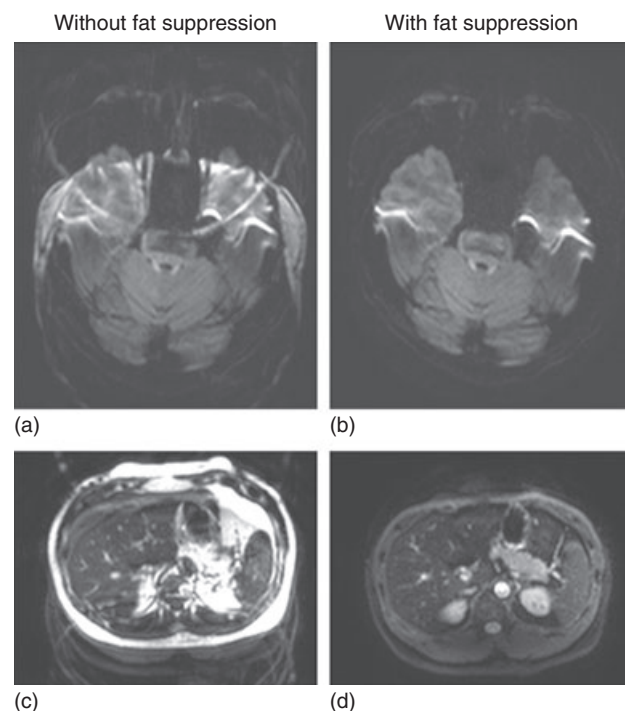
Clinical examples of the utility of CHESS fat-suppression MRI protocols in minimizing chemical-shift artifacts from fat along the phase-encoding direction in (a, b) diffusion-weighted imaging with an echo-planar acquisition and in (c, d) abdominal imaging owing to respiratory motion. All images were acquired on a 3 T Achieva platform from Philips Healthcare. (Courtesy of Jonathan M. Chia, M.S., Philips Healthcare)
